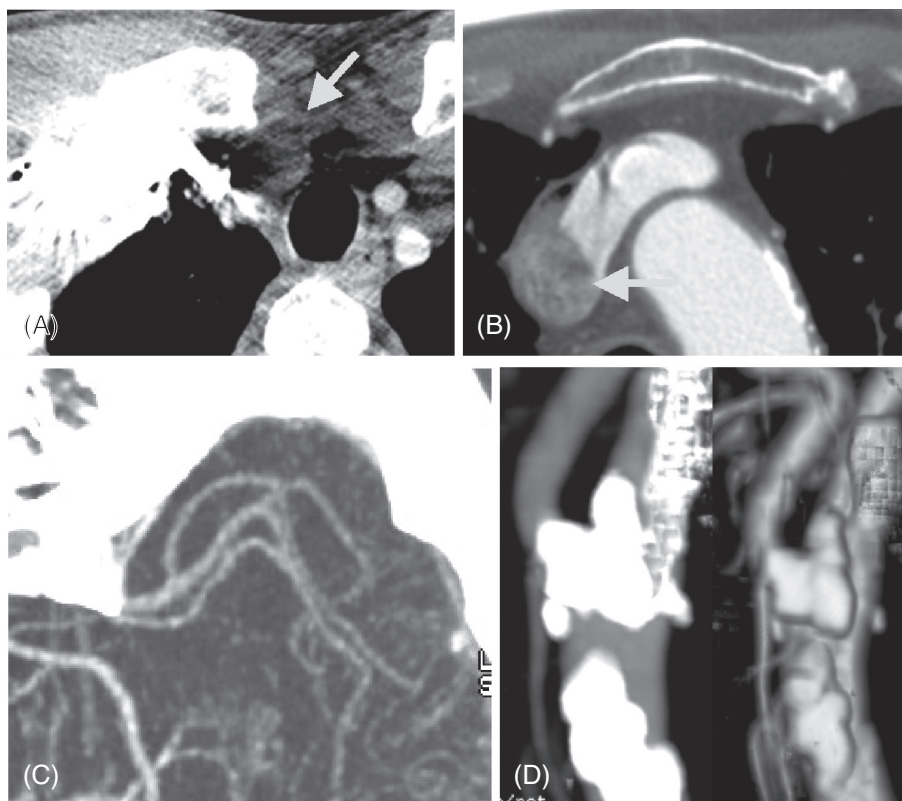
Pitfalls in CTA imaging and post-processing: Streak artifact from undiluted inflowing contrast can obscure proximal great vessel segments (A, arrow). “Pseudo-thrombus” appearance from incomplete contrast mixing of unopacified and opacified blood can occur in the superior vena cava (B, arrow). “Pseudo-beading” artifact can occur due to superimposition of background noise on poorly opacified vessels on maximum-intensity projection views (C). Thick atherosclerotic calcification overlying lumen can preclude residual luminal diameter measurement on maximum-intensity projection and volume-rendered (VR) views (D).
